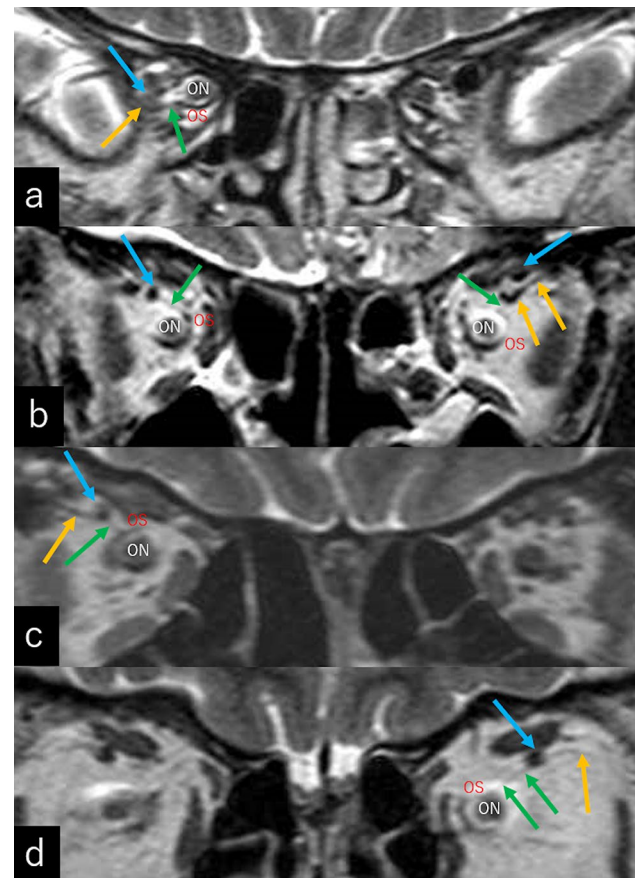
Coronal T2-weighted magnetic resonance images of different patients at the level of the posterior (a), middle (b), and anterior (c, d) thirds of the retrobulbar orbits showing the septal band with varying lengths that connects between the hammock suspending the superior ophthalmic vein and the optic sheath [a–d, green arrow(s)]. *ON*: optic nerve; *OS*: optic sheath; blue arrow: superior ophthalmic vein; orange arrow(s): hammock suspending the superior ophthalmic vein
